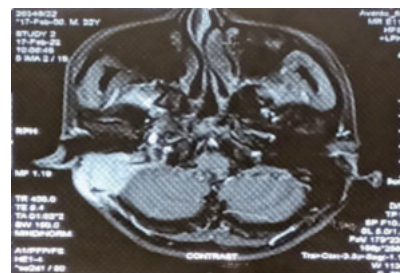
T2 MRI showing hyperintense lesion in right mastoid
